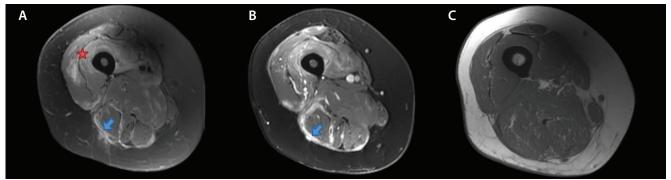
Muscle MRI findings in dermatomyositis include a marked T2 hyperintensity in thigh muscles, especially in the quadriceps (star), and along the fascial layers, especially in the biceps femoris (arrow), with evidence of subcutaneous fat edema on a T2-fat suppressed sequence (A). A post-gadolinium sequence (B) shows marked peripheral enhancement along the fascial planes (arrow). A T1-sequence (C) shows no significant abnormality.
